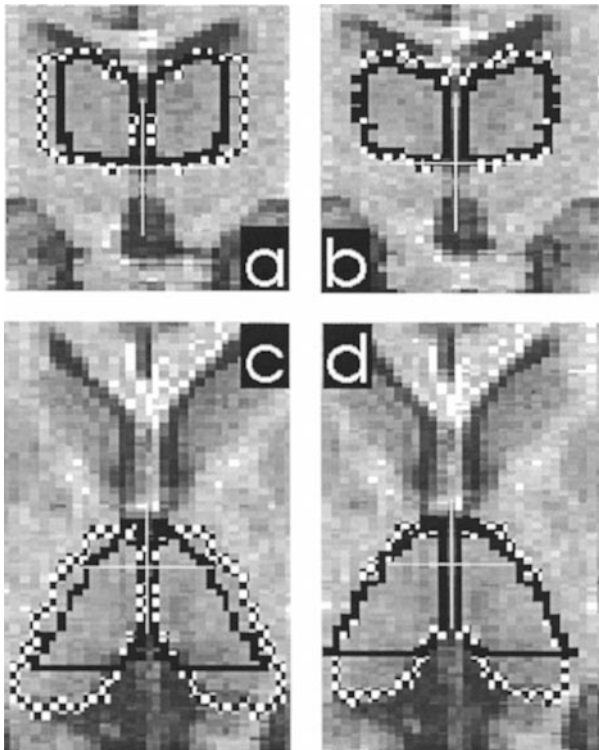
Thalamic borders from sagittal (checkerboard) and frontal (black) digital series in superposition with MR images re-sliced parallel to ACPC. Frontal (a, b, 5 mm occipital to midinter-commissural point) and horizontal (c, d, 6 mm dorsal to ACPC line) views. Frontal series does not cover pulvinar (black horizontal line in c and d gives occipital border of frontal series). Left column (a,c) before, right column (b,d) after spatial normalisation based on regression analysis of centres of gravity
